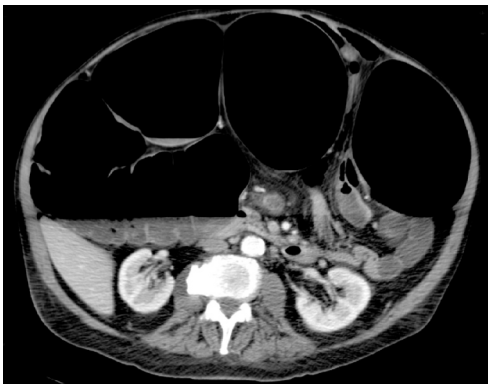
CT-scan showing massive distension of the colon (but not of the small intestine).
